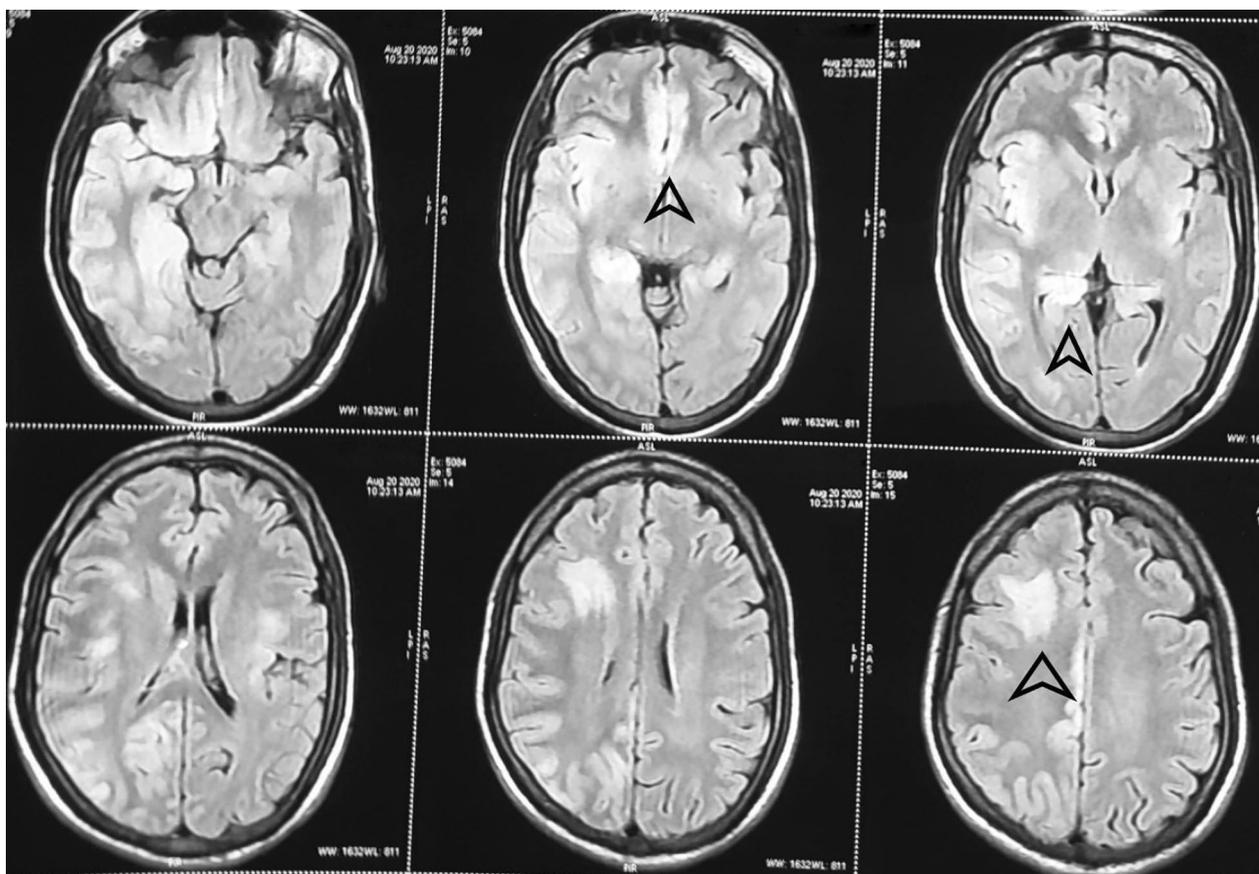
T2 FLAIR imaging reveals bilateral frontal, temporal and parietal T2 FLAIR hyperintensity (right side affected more than left side)
